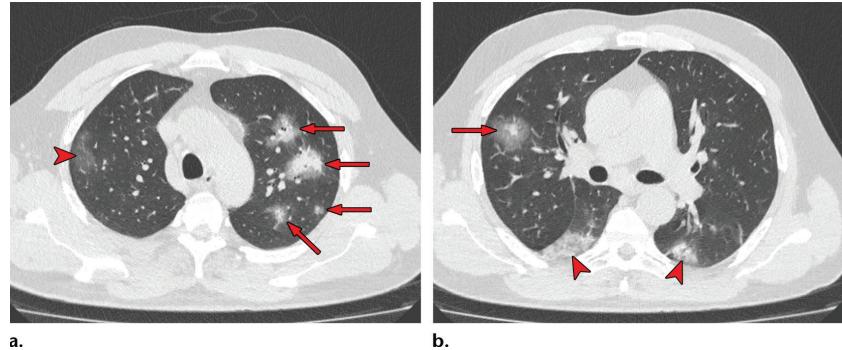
Halo sign in a 55-year-old man with RT-PCR-test–proven COVID-19. Axial nonenhanced chest CT images show consolidations surrounded by ground-glass opacities (arrows) in both upper lobes, findings consistent with the halo sign. There is a ground-glass opacity in the right upper lobe (arrowhead in a) and consolidation in both lower lobes (arrowheads in b).
